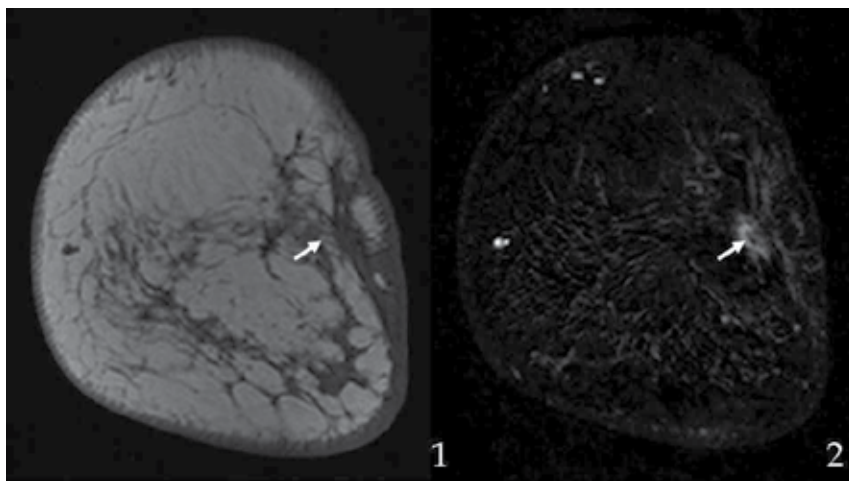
A woman with a personal history of infiltrating ductal carcinoma of the left breast treated with surgery and radiotherapy. One and a half years later, hyperintense areas are seen adjacent to the surgical scar on T1-weighted images (1), with peripheral enhancement (2) (arrows). It is essential to rule out relapse. Vacuum-assisted biopsy: Fat necrosis.
